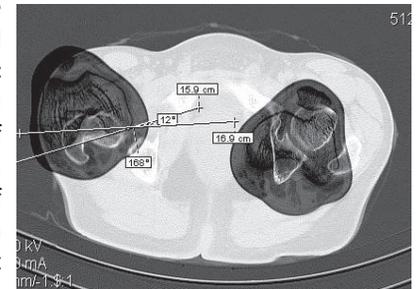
CT-scan of bilateral hip and knee revealed neck anteversion of minus 120 on right side (retroversion of 120) and plus 170 on left side
